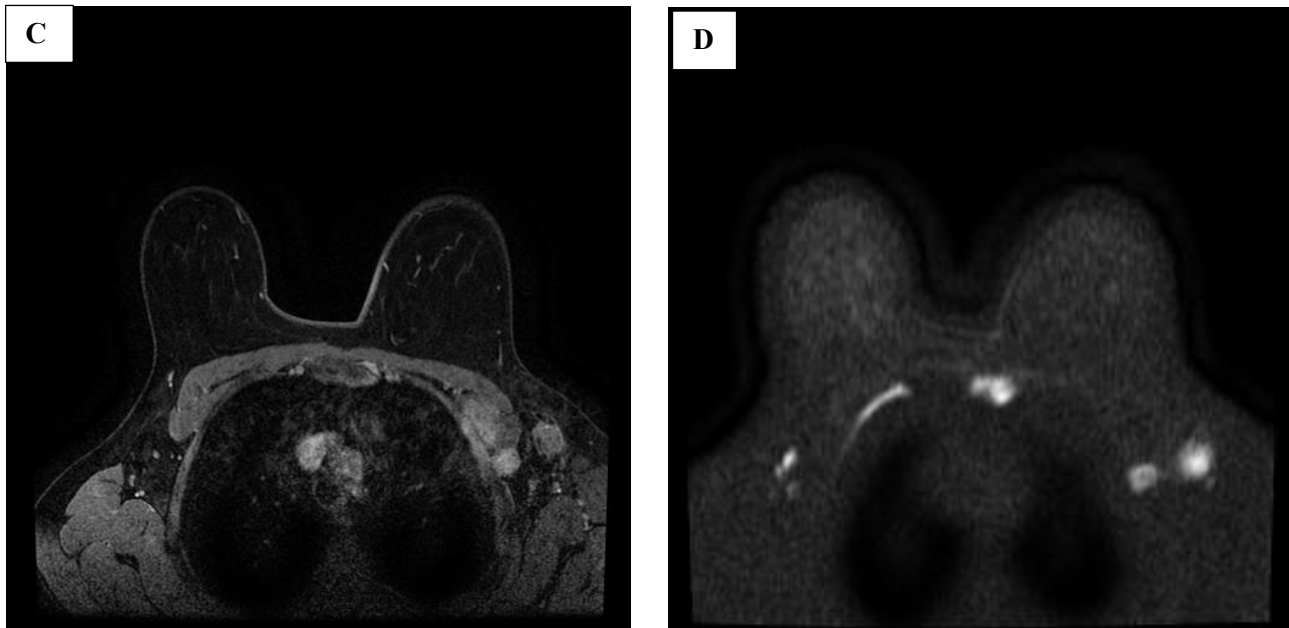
Abbreviated MRI evaluation of axillary lymphadenopathy in breast cancer: 32-year-old woman with diagnosed invasive ductal carcinoma of the right breast. (a): T1-weighted coronal image without fat saturation and contrast demonstrates a hypointense lymph node in the right axilla. (b): T1-weighted coronal image with contrast and fat saturation highlights the lymph node with increased signal intensity. (c): T1-weighted axial image with contrast further enhances visualization of the pathological lymph node. (d): Axial diffusion-weighted imaging (DWI) reveals restricted diffusion, consistent with metastatic involvement.
